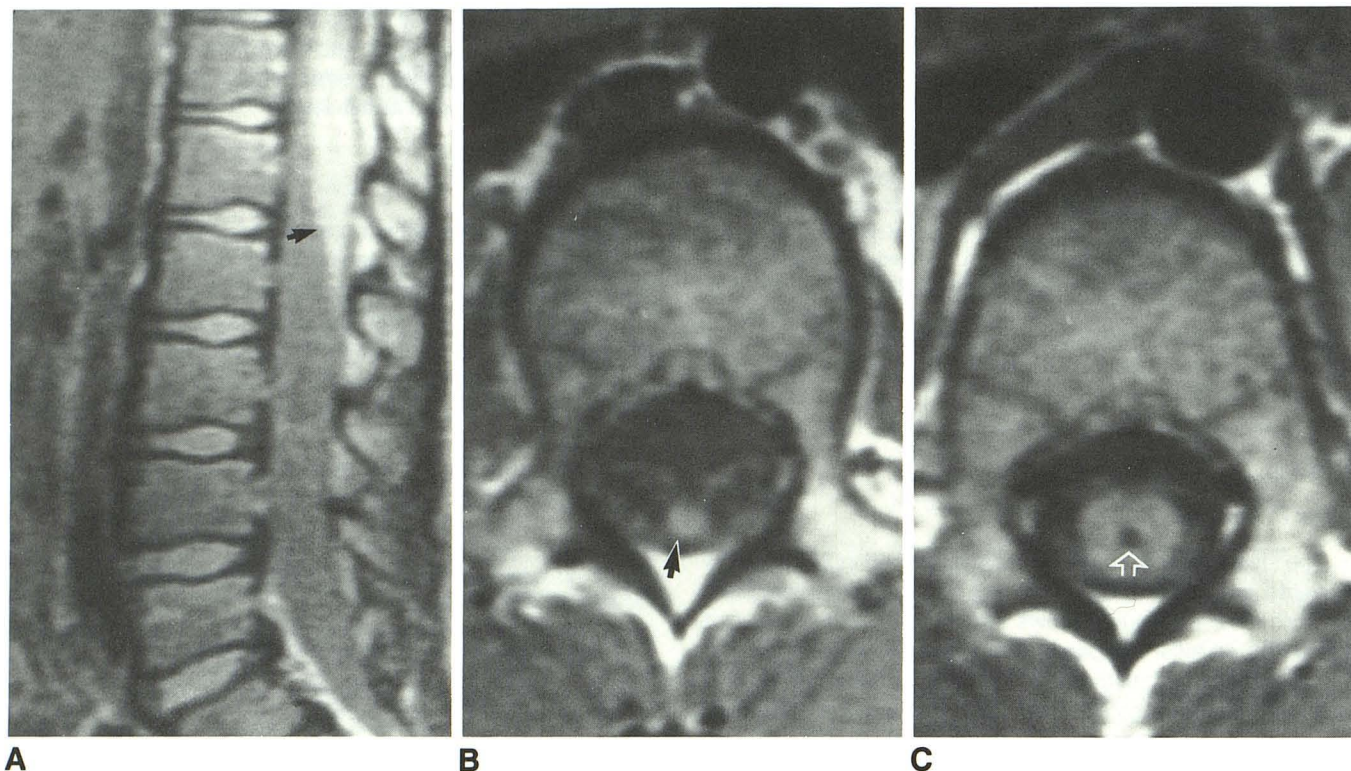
Case 21: 5-year-old boy with urinary incontinence. A and B, Spin-echo sagittal, 1000/40 (A) and axial, 1000/20 (B), images confirm position of tip of conus (arrows) to be at L1–L2 interspace. C, Only other radiographic clue is syringohydromyelic cavity/myelomalacia (arrow) (possibly seen on sagittal image as well) from mid T11 to L1–L2 region.
